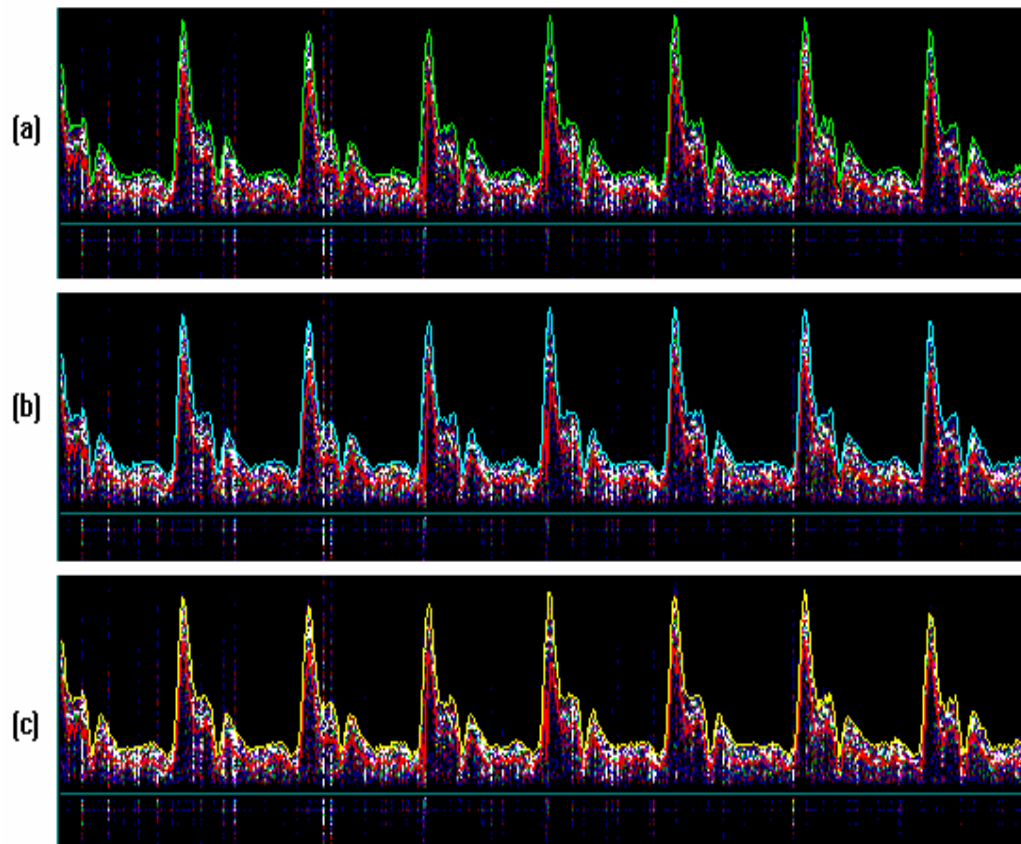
Maximum frequency envelopes obtained from a Doppler signal recorded from a carotid artery; (a) Modified geometric method, (b) Modified threshold method, (c) Simple threshold method.
